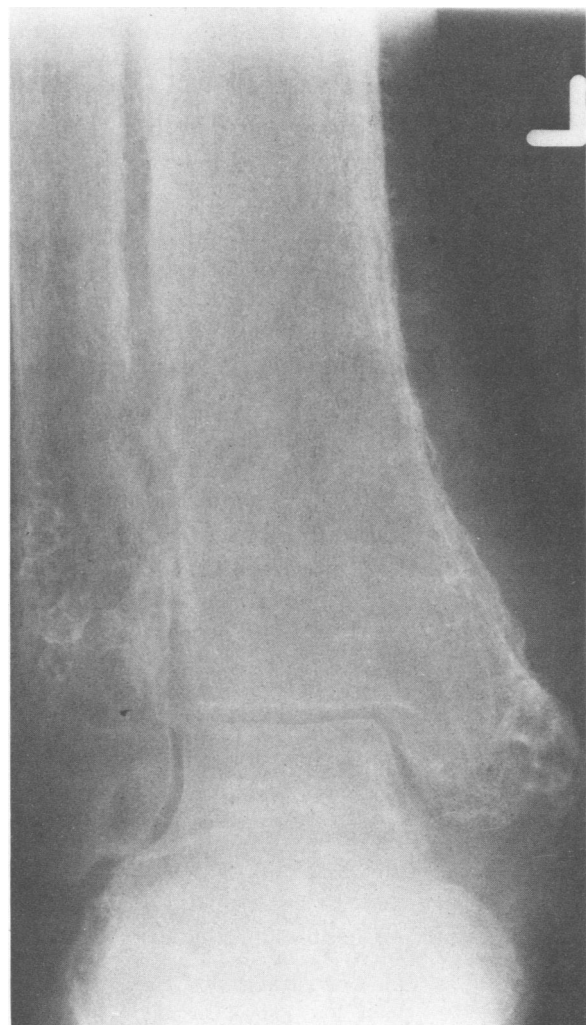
Radiograph showing periostitis in distal ends of tibiae and fibulae.
